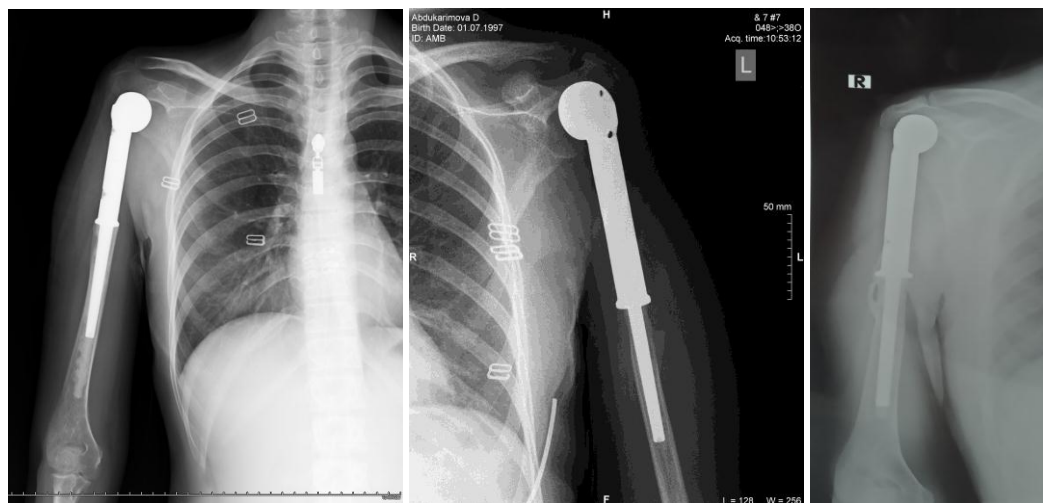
№ 19: Radiography after surgery.
